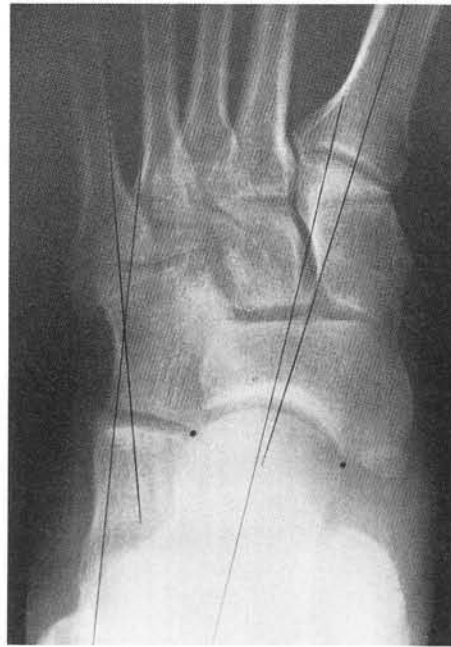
Dorsoplantar neutral position radiograph. Total restoration of alignment has been achieved. This is the desired position of fusion for this patient.
